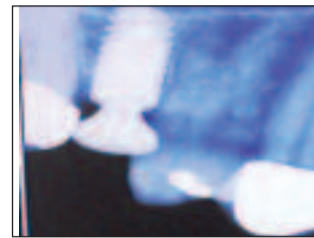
Immediate post-op radiograph with implant in place
